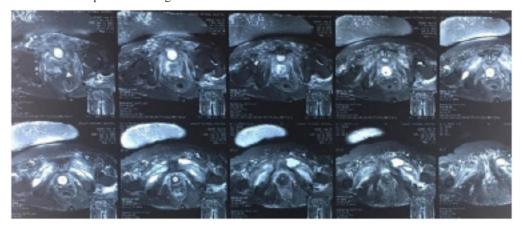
MRI T2 weighted images axial cuts of pelvis and thigh area showing pockets of abscess of muscles of medial compartments of both thighs. Largest one in left groin measuring 4.8 * 3.1 cm.
